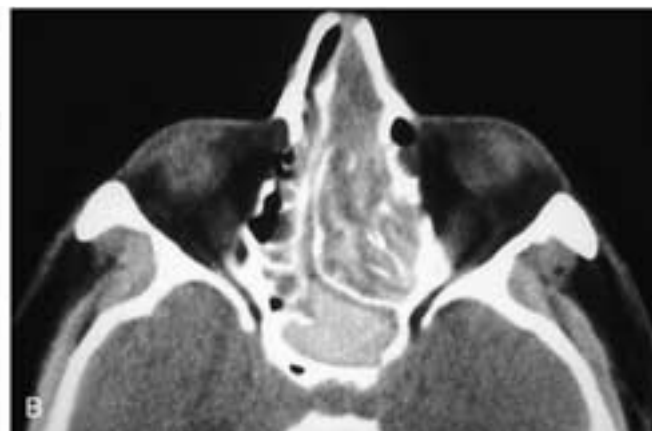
Coronal CT scan (A) shows an expansile right nasoethmoid mass that has displaced the nasal septum to the left (*large arrow*). The mass has also focally broken into the floor of the anterior cranial fossa (*small arrow*). Within the mass are discrete high-attenuation polypoid masses embedded within mucoïd secretions. There are also inflammatory changes in the left ethmoid sinuses. This patient had polyposis. An axial CT scan (B) on another patient shows a high-attenuation soft-tissue mass in the sphenoid sinus that is separated from the sphenoid sinus's bony wall by a zone of mucoïd attenuation. There also is an expansile left nasoethmoid mass that has discrete high-attenuation polypoid areas within mucoïd secretions. This patient had polyposis and a sphenoid sinus polyp.
